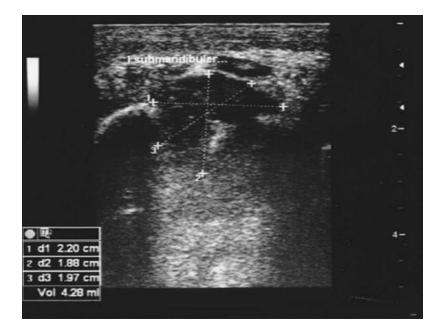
Sonogram showing the submandibular space abscess.
